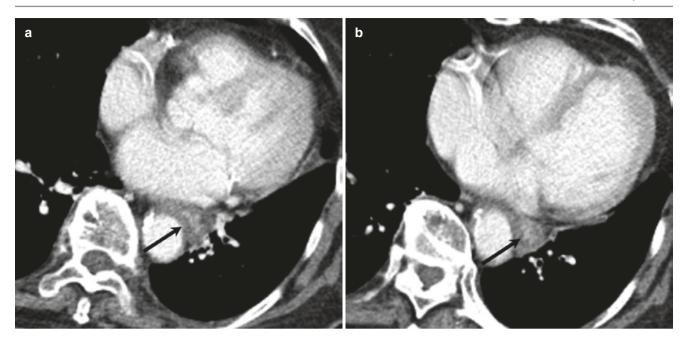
"Target sign" in viral esophagitis. (a, b) Axial CT images show enhancement of esophageal mucosa with hypodense submucosa
